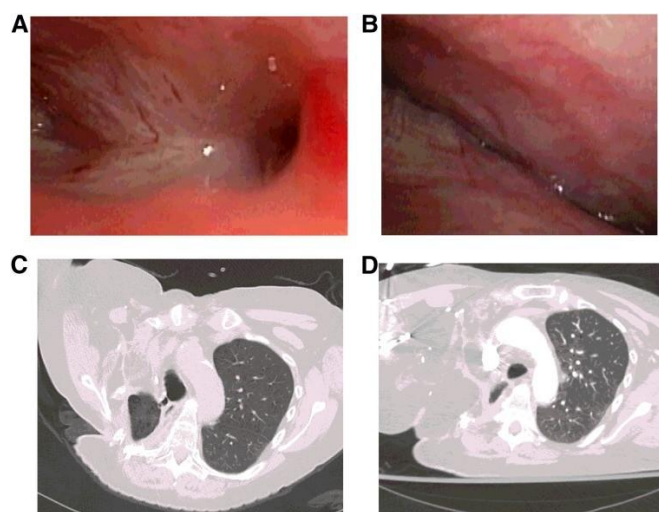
Preoperative imaging showing size and location of fistula, and postoperative imaging demonstrating disease resolution. (A): Preoperative bronchoscopy demonstrating large bronchopleural fistula (BPF) cavity and lateral extension of fistula tracts. (B): Postoperative bronchoscopy (3 months) demonstrating progressive healing of BPF site. (C): Preoperative computed tomography scan demonstrating large BPF with connection to atmosphere (additional axial slices inferiorly). (D): Postoperative computed tomography scan (16 months) demonstrating resolution of BPF.
